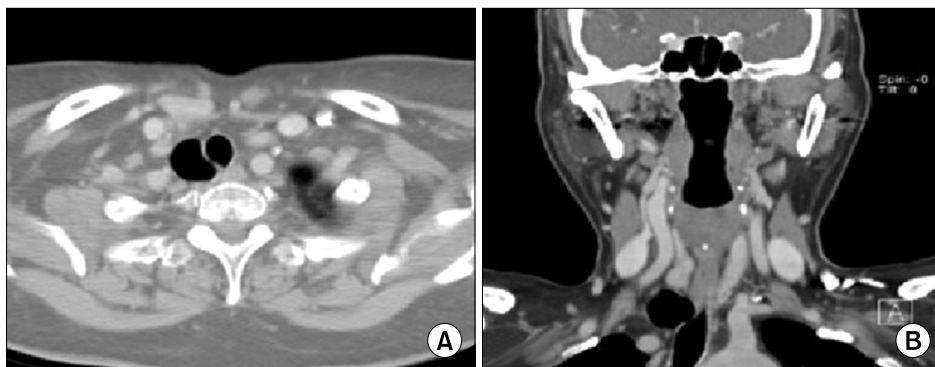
(A, B) Initial preoperative computed tomography scan showing the tracheal diverticulum positioned on the right posterolateral aspect of the trachea.
